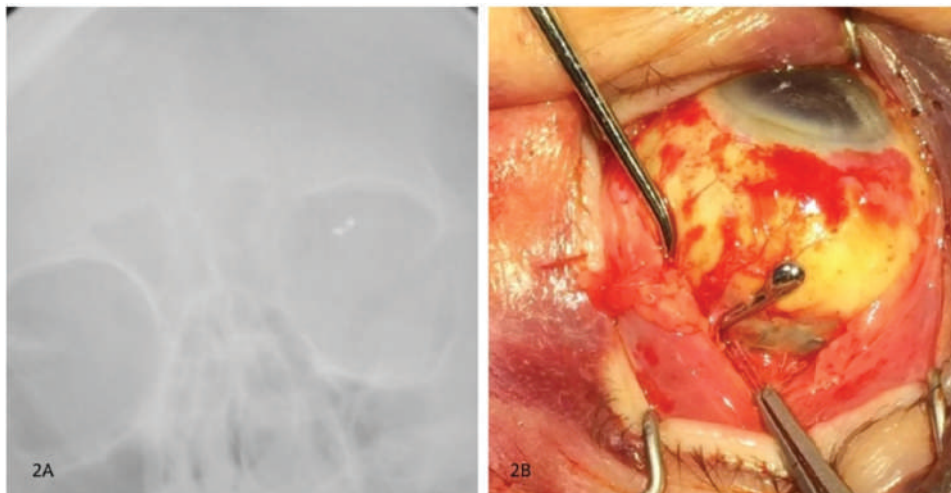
(A) Intraoperative X-ray demonstrating metallic foreign body in left orbit to be symmetric surgical clip. (B) Metallic surgical clip used to secure buckle located superonasally.
